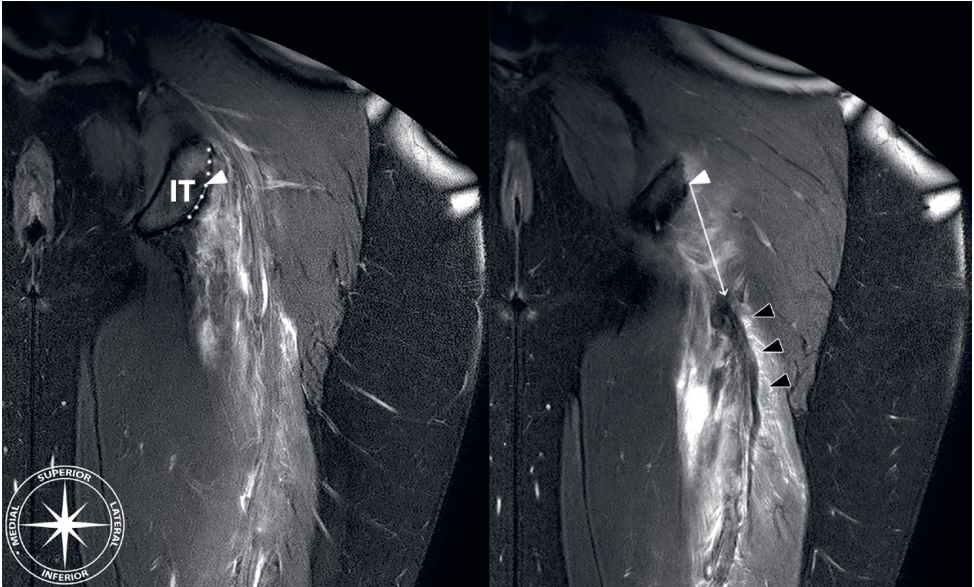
Direct retraction measurement. First, the point representing the centre (white triangle) of the proximal hamstring origin on the upper region (dotted line) of the ischial tuberosity (IT) is determined. From this point, the direct (i.e. shortest) distance (white arrow) to the most proximal part of the hypointense tendon stump (black triangles) was measured (in mm). Note that determining the anatomic landmarks is done on different images within 1 magnetic resonance imaging sequence.
